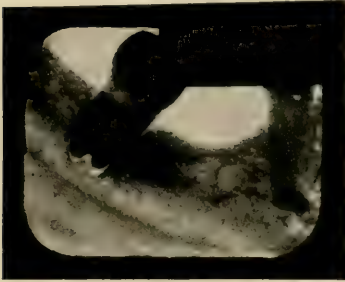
Unusually large periapical space at the apex of the roots of the lower molar; appearance similar to that of a very small abscess.
